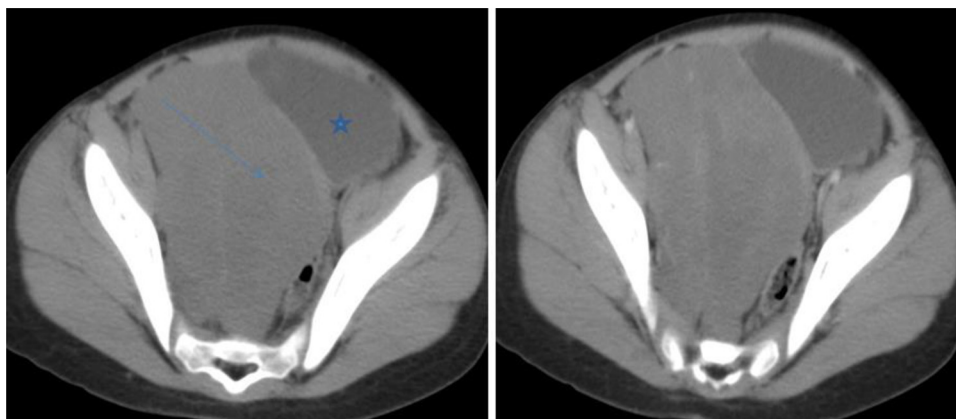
Axial plane abdominopelvic CT scan before and after injection of contrast medium showing a well-limited presacral mass, hypodense raised after injection of contrast medium (arrow), displacing the bladder (star).
